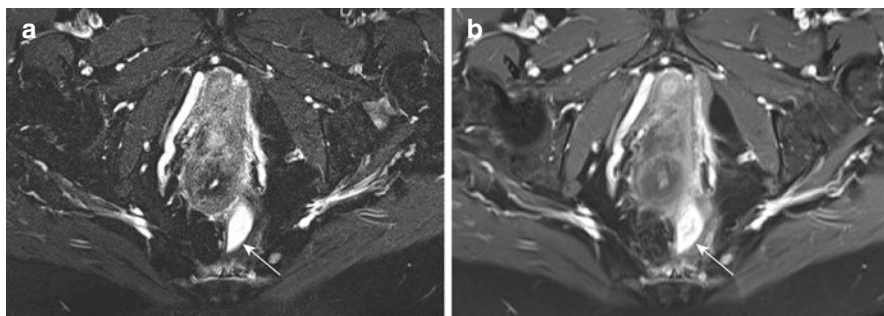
Hyperintense collection (arrow) which can be interpreted as fluid or granulation tissue on a T2-weighted fat-suppressed sequence (a). The contrast-enhanced T1-weighted sequence (b) shows almost full enhancement indicating a circumscribed area with granulation tissue and very little fluid (compare to Fig. 8.3)
